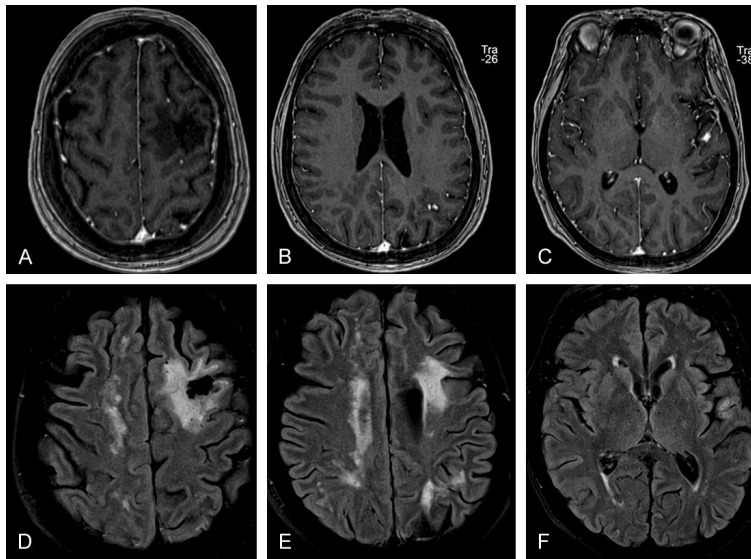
MRI (4 years later) with gadolinium shows: (A-C) T1 images with new nodular enhancement in the left frontal cortex (D), two small lesions in the left parietal cortex (E), and changes in the left temporal cortex (F). T2 reveals edema in the left frontal cortex and bilateral hyperintensities on T2 FLAIR [55].
